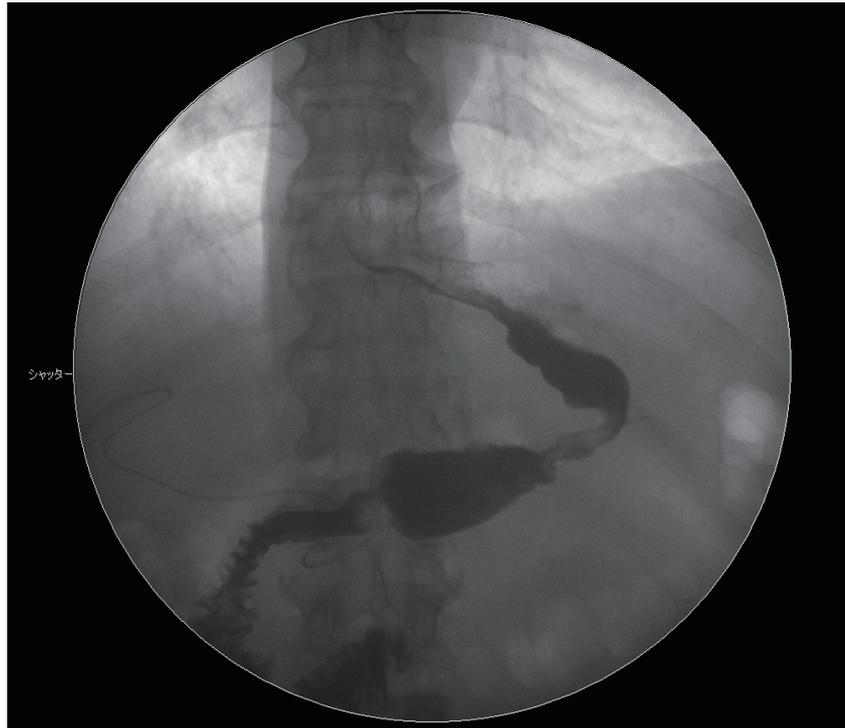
Upper gastrointestinal tract X-ray examination.
